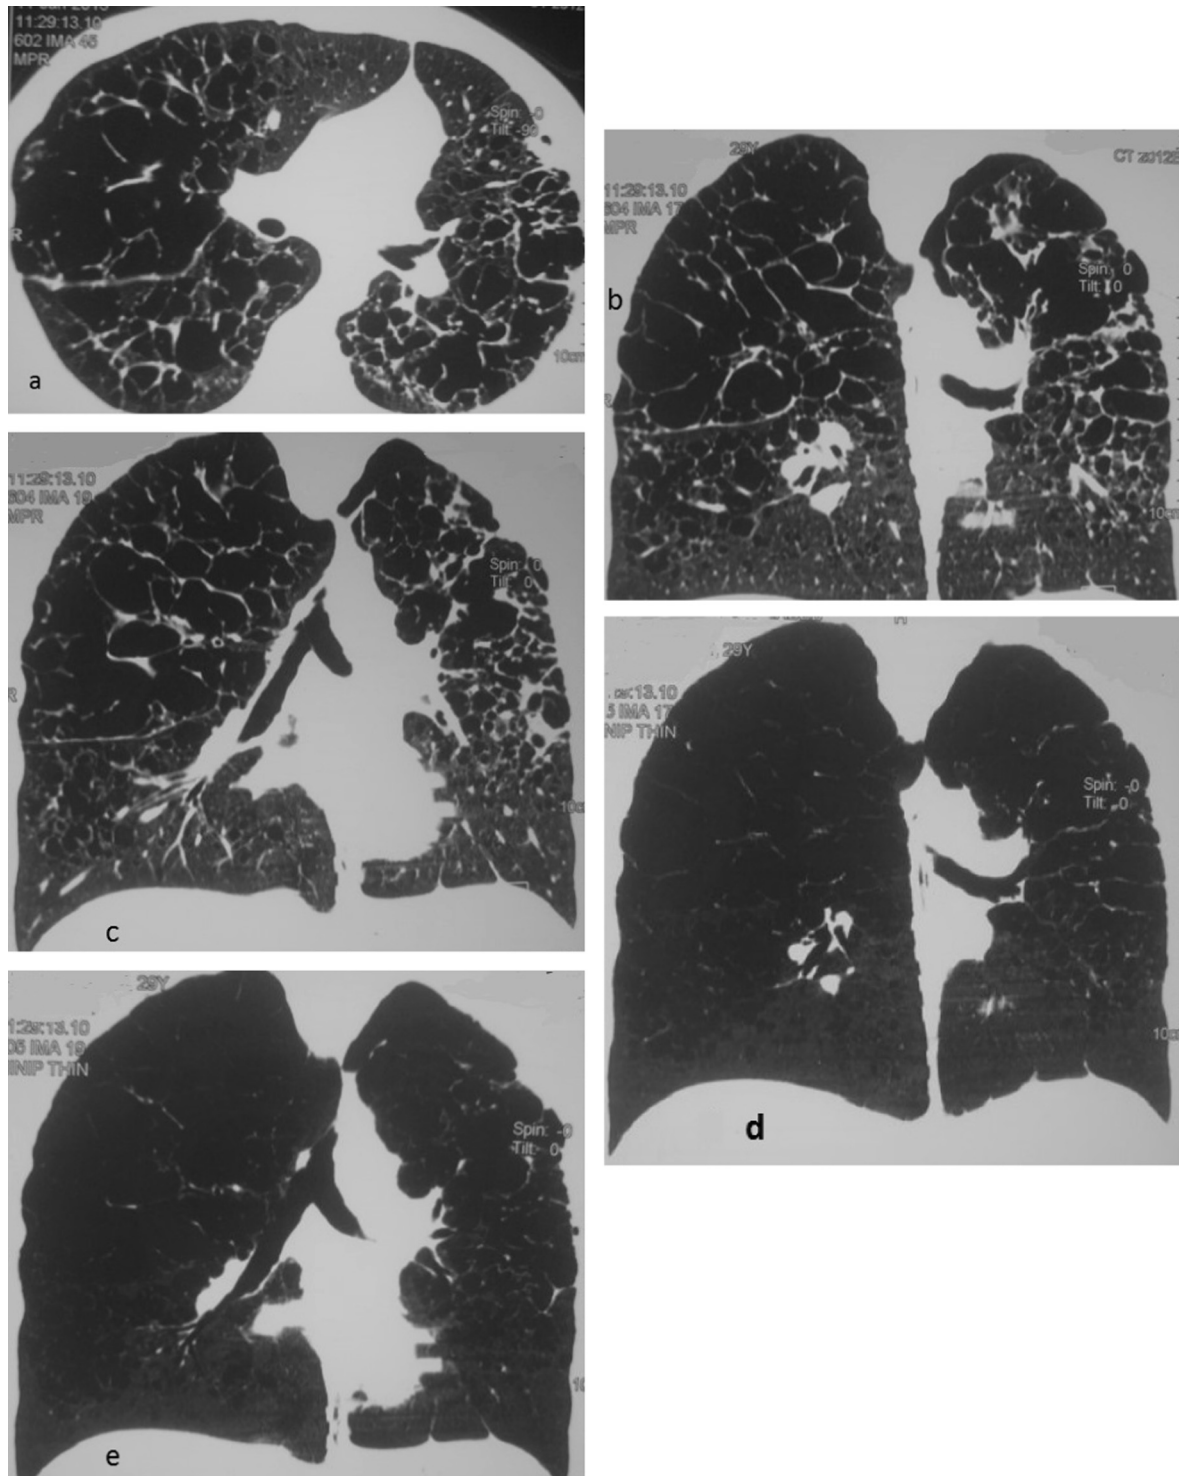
(a–f): A 46-year-old female diagnosed with pulmonary LAM (Lymphangiomyelomatosis). HRCT axial (a, b) and coronal (c), sag (d) images show bilateral multiple variable sized cysts having imperceptible walls within the otherwise normal lung parenchyma. MinIP coronal image (e, f) show the bilateral numerous cysts even the smaller ones that were not seen in the HRCT images.
